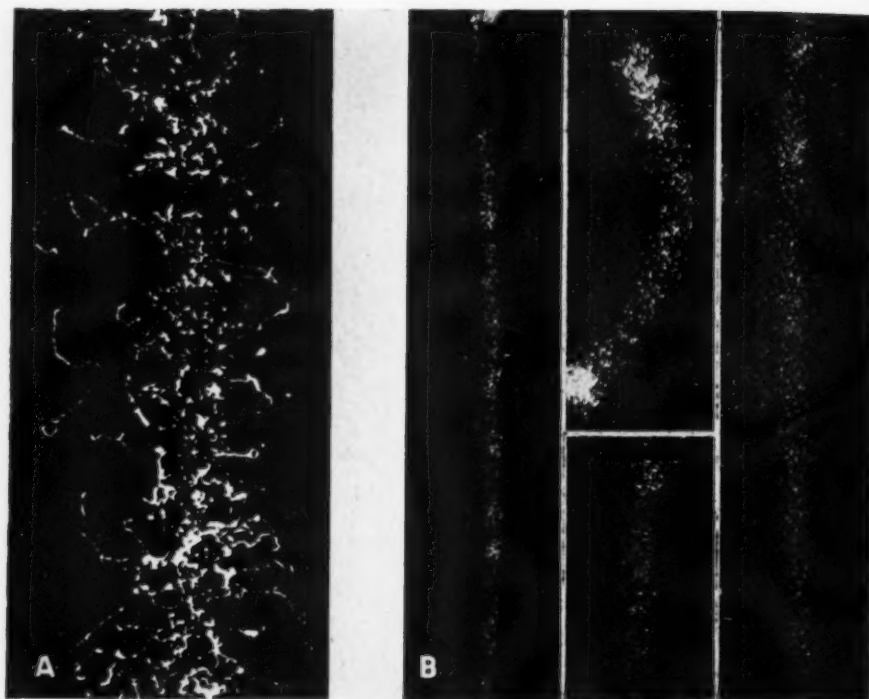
A. In the Wilson cloud chamber, water droplets condense on the ions produced by photo-electrons from a narrow beam of x-rays (low voltage). (From Wilson.) B. Ionization along paths of very high-speed electrons, broadened by diffusion. Note uneven distribution (clusters). (From Corson and Brode: Phys. Rev. 53: 773-777, 1938.)
